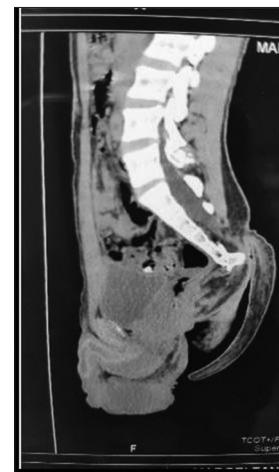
Sagittal image of computed tomography scan showing tip of coccyx everted toward base of tail. This everted bony spur is reason for pain while sitting
